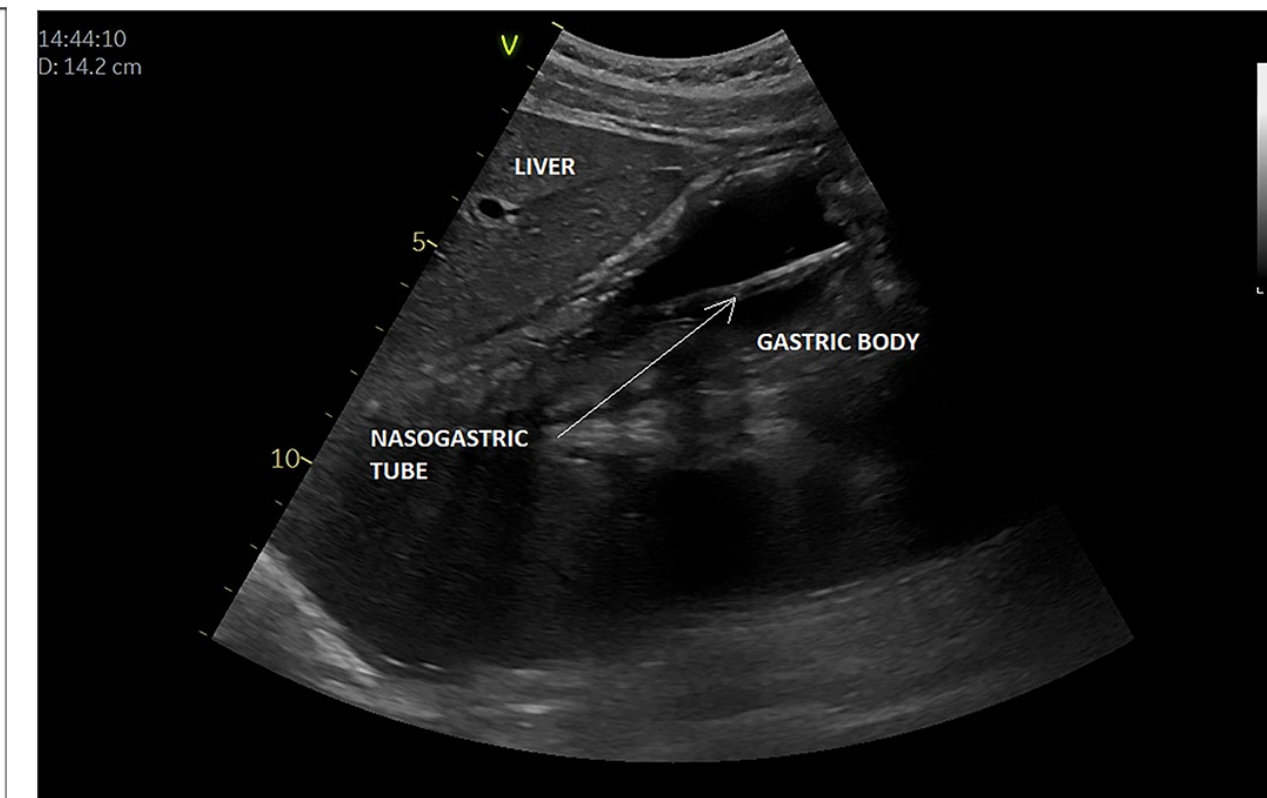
Nasogastric tube placement in gastric body on ultrasonography (Valla FV, *Frontiers in Pediatrics*. 2022.)
